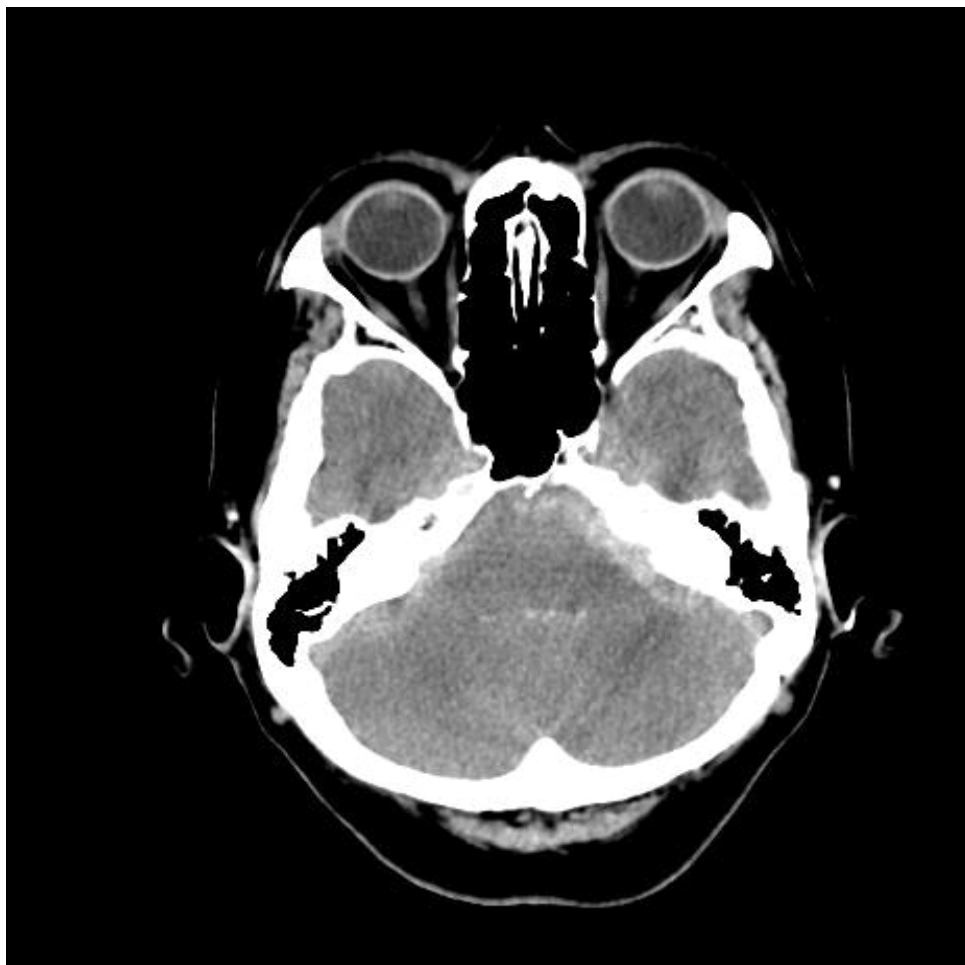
Axial computed tomography scan revealed thick subarachnoid hemorrhage in the left cerebellopontine angle. Lt.: Left; Rt.: Right
